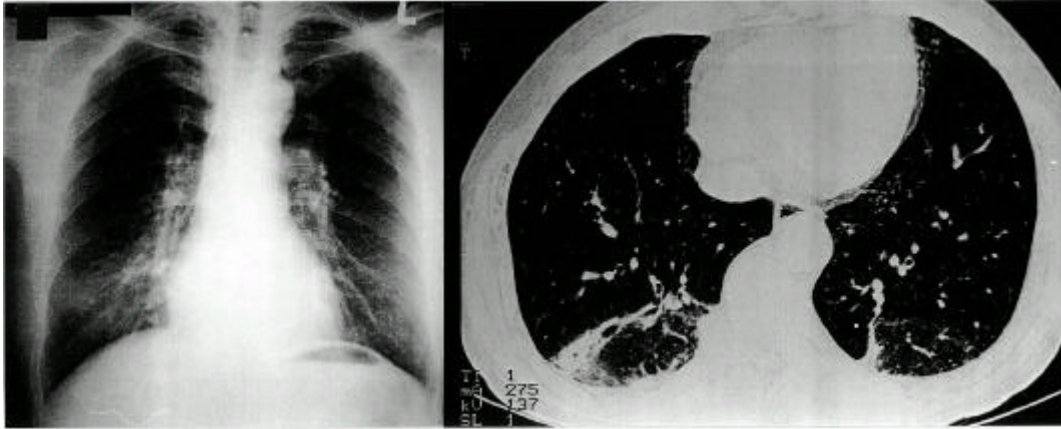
Twenty days after prednisolone treatment and discontinuation of bucillamine, chest radiograph and HRCT revealing improved lesions.
